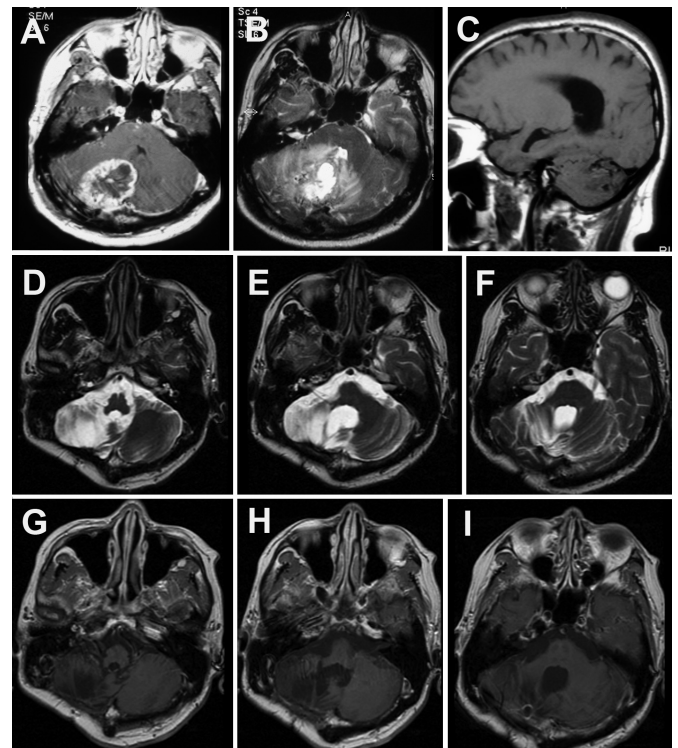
Preoperative axial T1 weighted with gadolinium (A), T2 axial (B) and T1 sagittal (C) without gadolinium magnetic resonance images (MRI) show an irregular, enhancing intraaxial right cerebellar mass with surrounding hyperintensity on T2 image and prominent flow voids on the sagittal image. A series of axial T2 (D-F) and T1 (G-I) MRIs with gadolinium obtained eight years after surgical resection, radiation and chemotherapy show an area of encephalomalacia but no enhancement showing no evidence of tumor recurrence.
